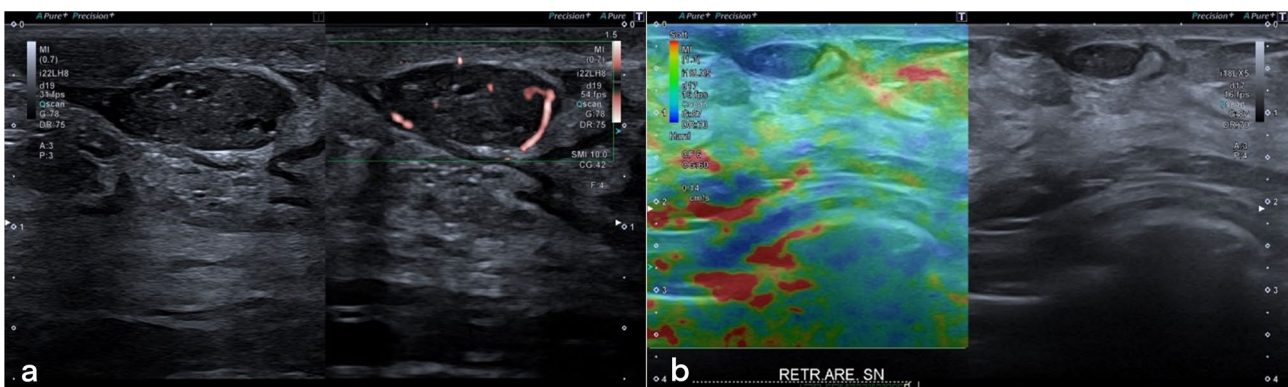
a Ultrasound shows a cystic lesion with a solid nodule inside with increased peripheral Doppler signal, adjacent to the nipple and the imaging of the stiffness with the aid of strain elastography (b)
